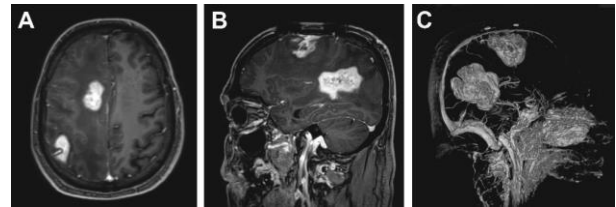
Multiple glioblastoma case; Tumors and vascular structures are observed in a- Axial contrasted MRI, b- Contrast sagittal MRI, c- 3D Angio Window Image.
